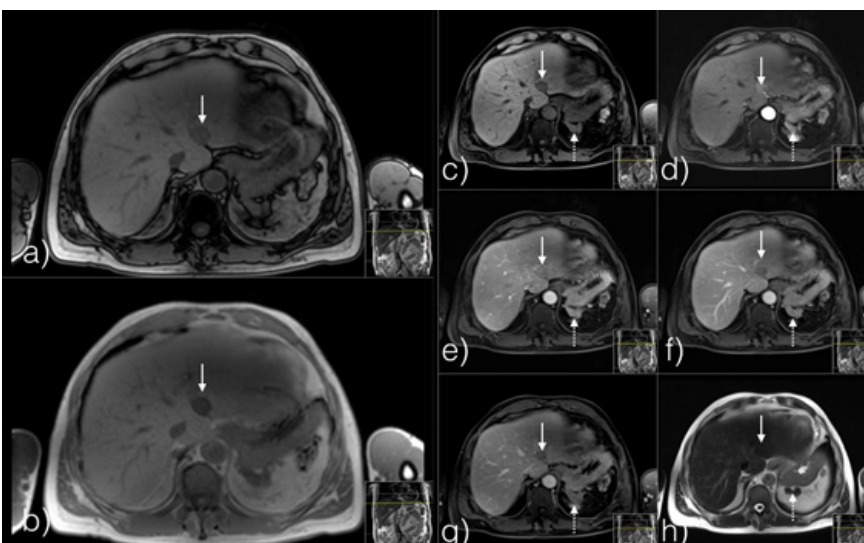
MRI of the abdomen – out (a) and in (b) phases show the hypointense nodule (arrow) in the segment 2. There is no loss of signal in the out-of-phase image to suggest fat content. Unenhanced T1-weighted image (c) shows the hypointense nodule (arrow). There is homogeneous enhancement of the nodule in the arterial phase (d) and washout during portal (e) and subsequent phases (f and g). These characteristics are concerning for hepatocellular carcinoma (HCC). On T2-weighted image without fat saturation (h) the nodule is isointense to the remaining hepatic parenchyma, which is not the most typical behavior of HCC. Note that the spleen is absent and that there is an image in the splenic bed (dashed arrow) with similar characteristics to the hepatic nodule described.
